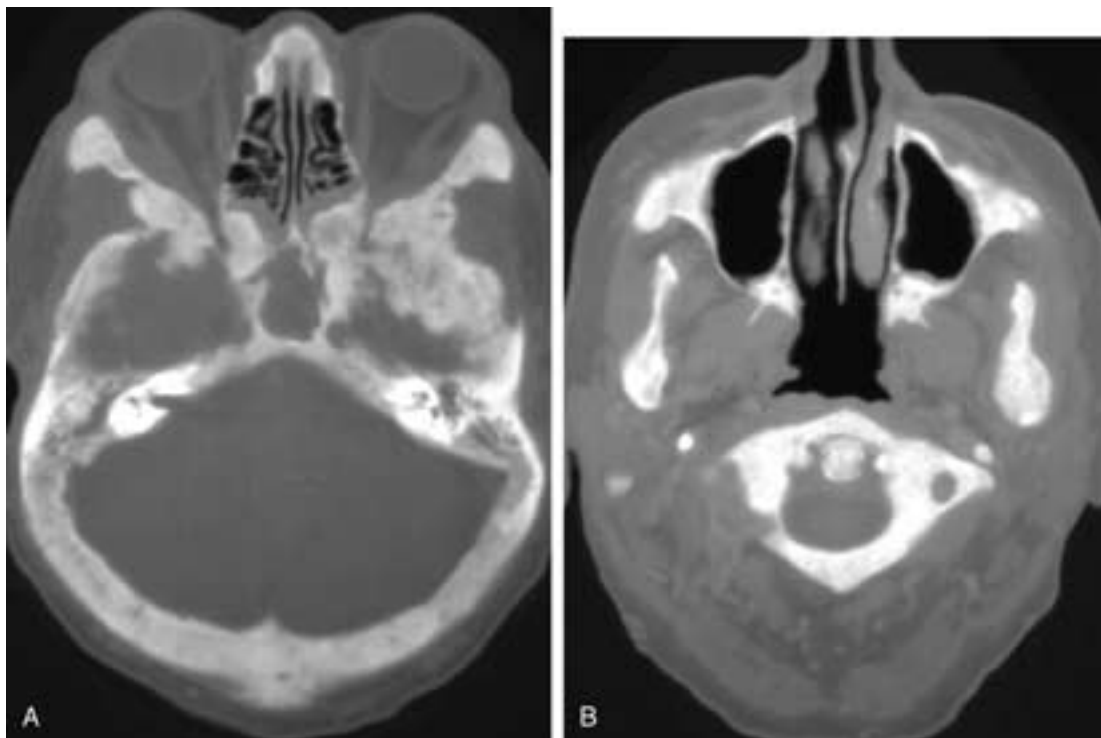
Axial CT scans through the orbits (A) and the maxillary sinuses (B) show that the bones of the skull base, upper cervical vertebra, and face are thicker and denser than normal. The bones have a slightly irregular contour, and there is poor detail of the trabeculae. This patient had Paget's disease.
